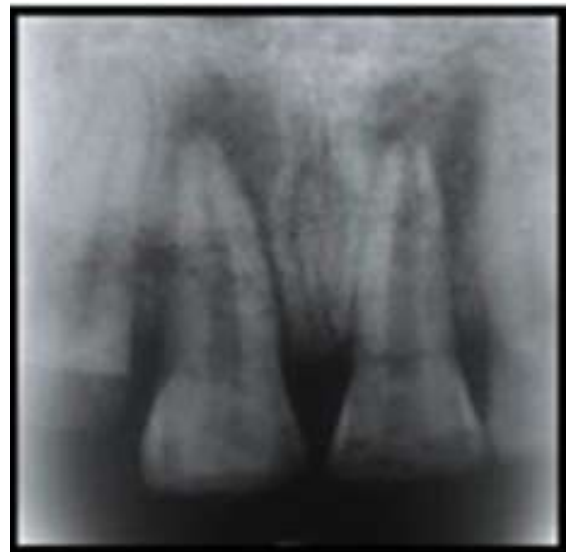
Pre-operative IOPA radiograph
